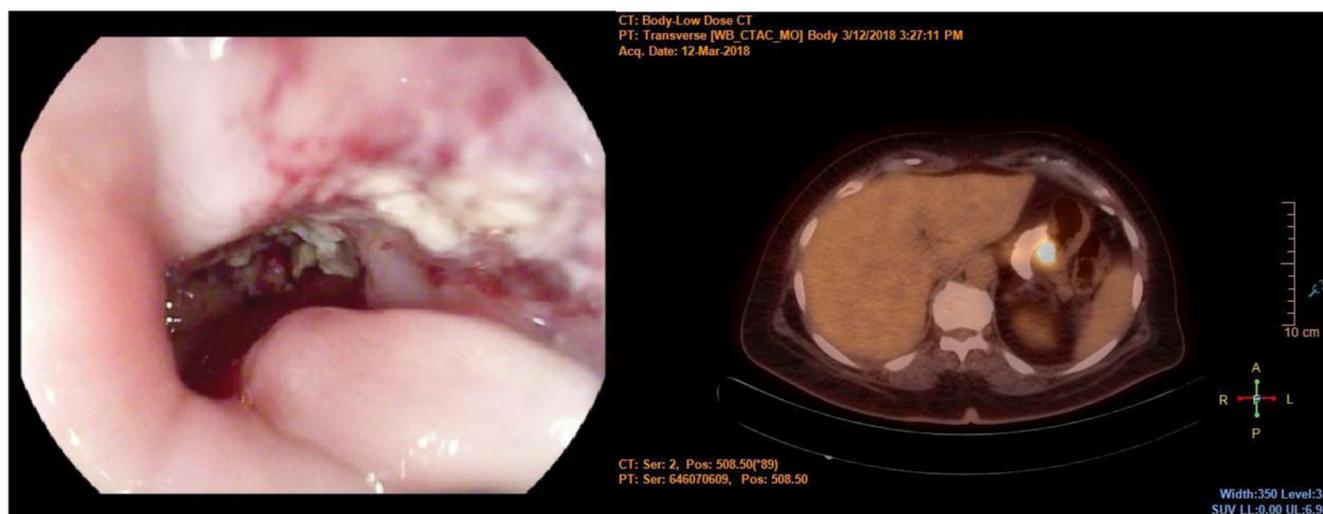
a Endoscopic view of the necrotizing ulceration near the lap band; b PET-CT shows hotspot with FDG affinity proximal of the gastric banding
